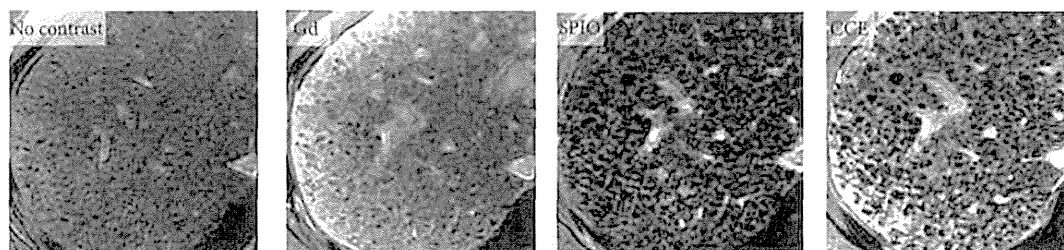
MR images of liver in 60-year old man with HCV-related cirrhosis. Noncontrast, Gd-only, SPIO-only, and CCE 2D breath-hold T1-weighted gradient-echo images of cirrhotic liver due to HCV. Abnormal reticular pattern of the liver parenchyma is better visualized on single-contrast-enhanced (Gd or SPIO) images than on unenhanced image and better visualized on CCE images than on single-contrast-enhanced images. Gd: gadolinium; SPIO: superparamagnetic iron oxide, and CCE: combined contrast enhanced.
